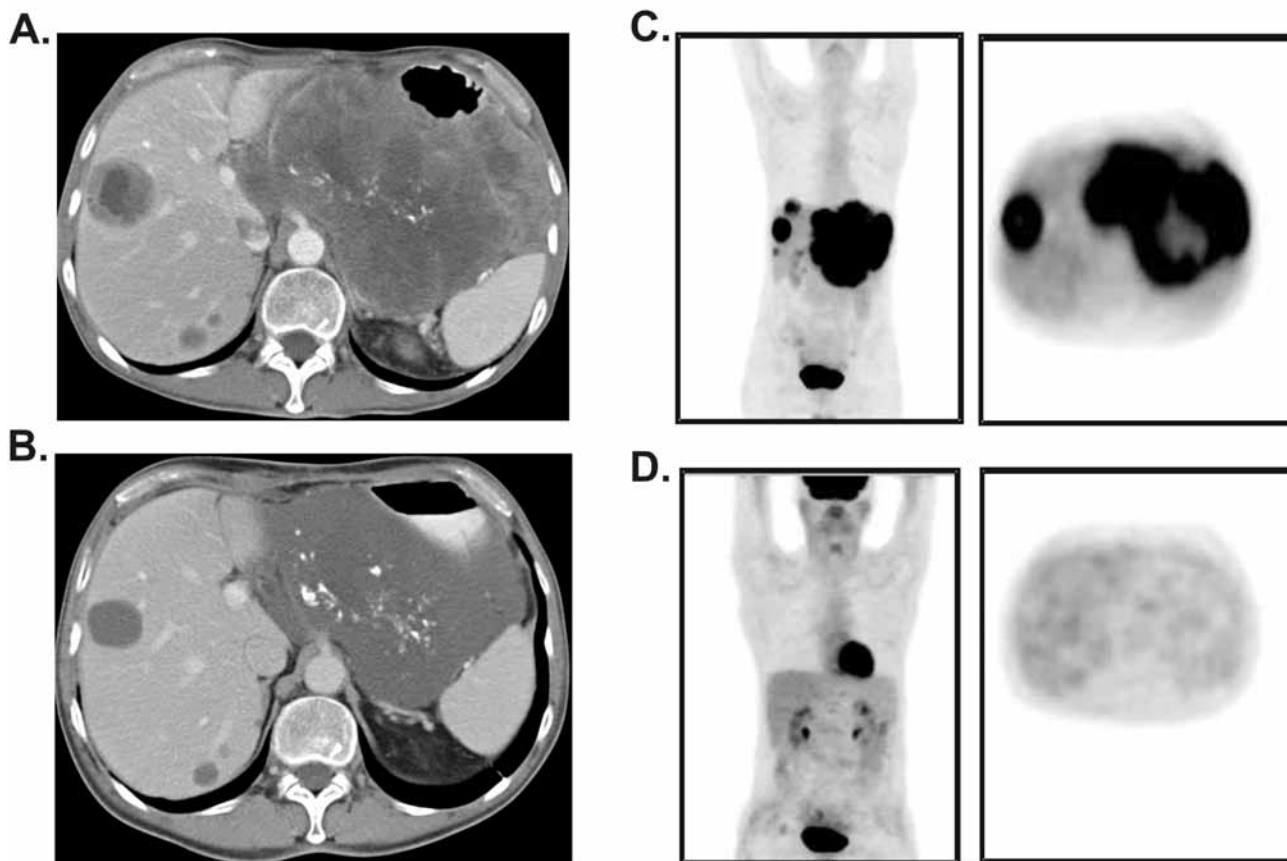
CT and FDG-PET scans of a patient with a metastatic GIST treated with imatinib mesylate.
